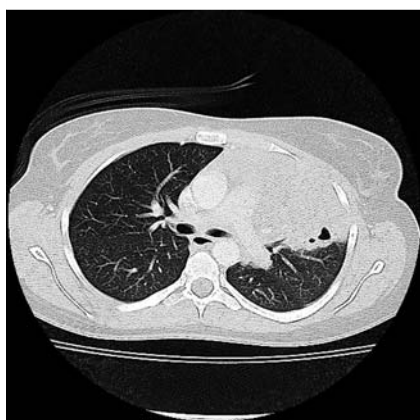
Chest-CT with consolidation of the left upper lobe.
